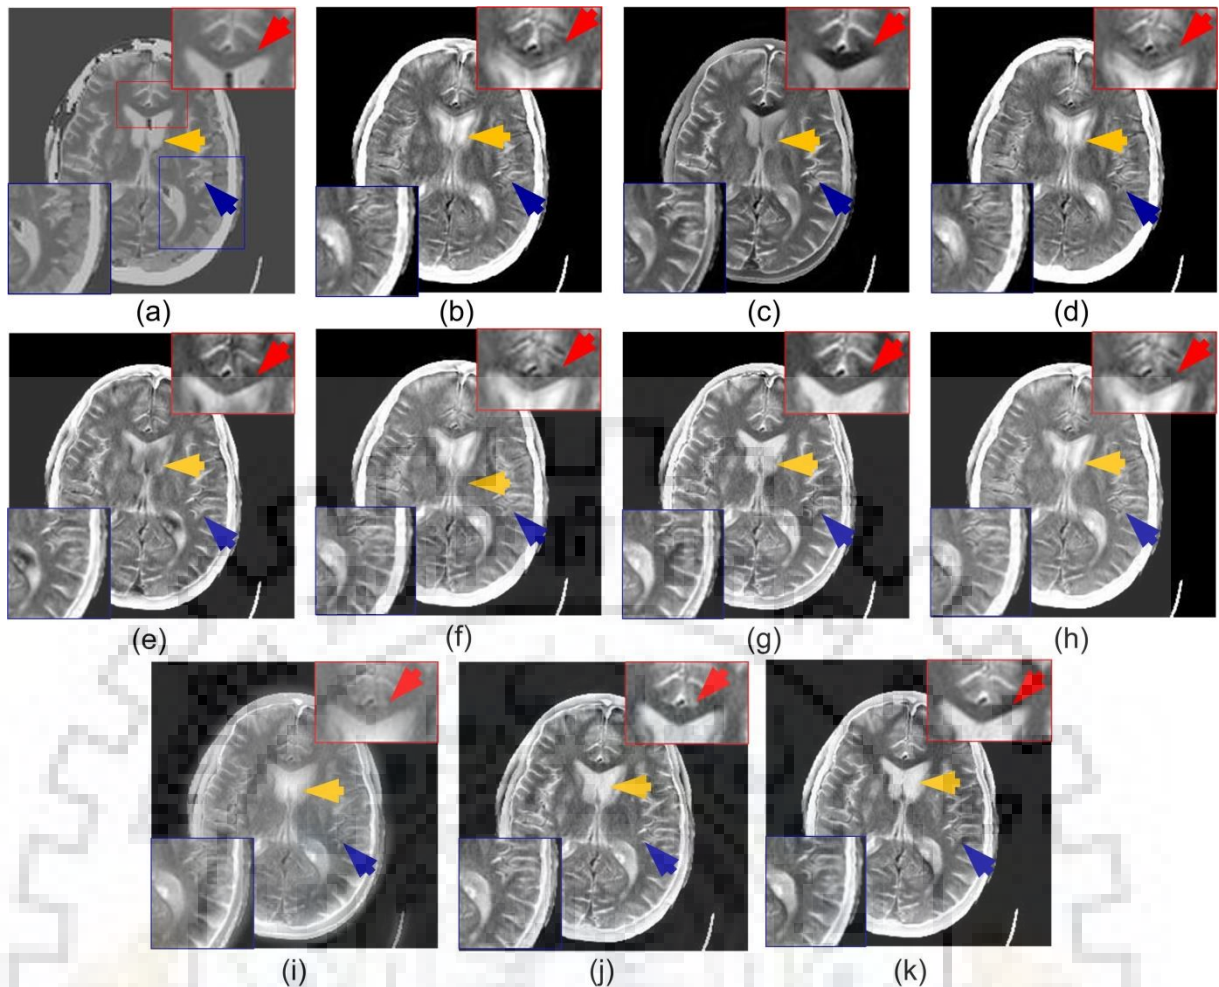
CT-MR image pair-4 shown in Figure 6.5. Comparison of fused images obtained by (a) Nirmla et al., 2016 [137] (b) Das and Kundu, 2012 [34] (c) Li et al. (GFF), 2013 [94] (d) Ganasala and Kumar, 2016 [48] (e) Yang et al., 2017 [203] (f) Zhu et al. (HMSD-GDGF), 2018 [218] (g) Liu et al., 2017 [111] (h) C-MIF method (i) Hermessi et al., 2018 [57] (j) Hou et al., 2019 [59] (k) Proposed CNN-MIF
